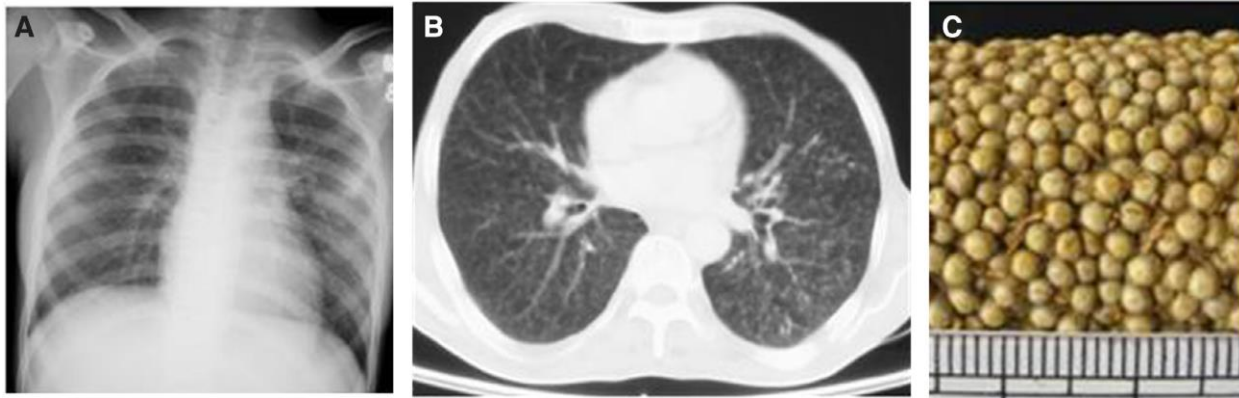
Chest radiograph (posteroanterior view) ( A ) and chest CT (lung window) ( B ) showing a classical miliary pattern. The nodules ( < 2 mm) evident in miliary tuberculosis resemble the grains of pearl millet ( Pennisetum typhoid, Baja) (C). Source form [11].
